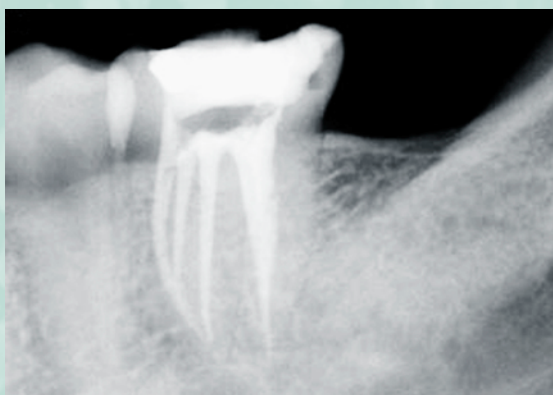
Postoperative radiograph with exaggerated distal angulation demonstrating a confluent mesiobuccal and middle mesial canal and a separate mesiolingual canal.
